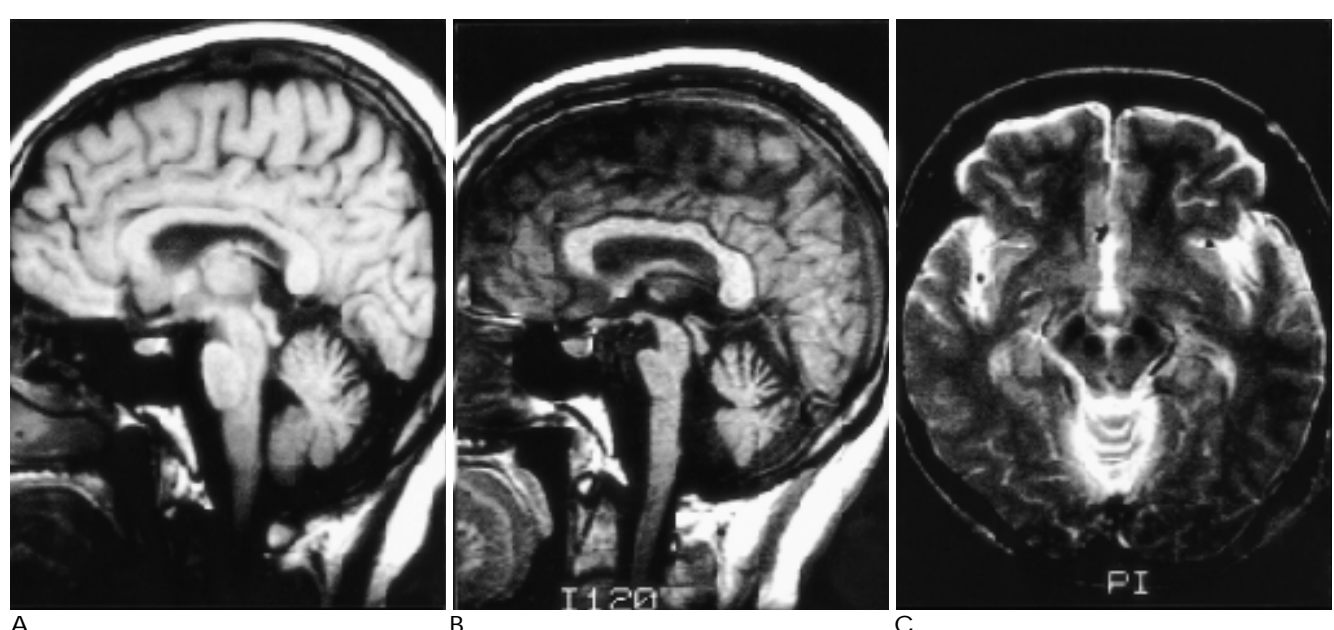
A. Sagittal T1-weighted image shows mild atrophy of the olive, pons and cerebellum. B. On follow-up MRI after 4 years, sagittal T1-weighted image shows progressed atrophy of the olive, pons and cerebellum. Combined cerebral atrophy is newly noted. C. On follow-up MRI after 4 years, axial T2-weighted image shows prominent decreased signal intensity of the substantia nigra and red nucleus. This signal change was not apparent on the previous MRI.
